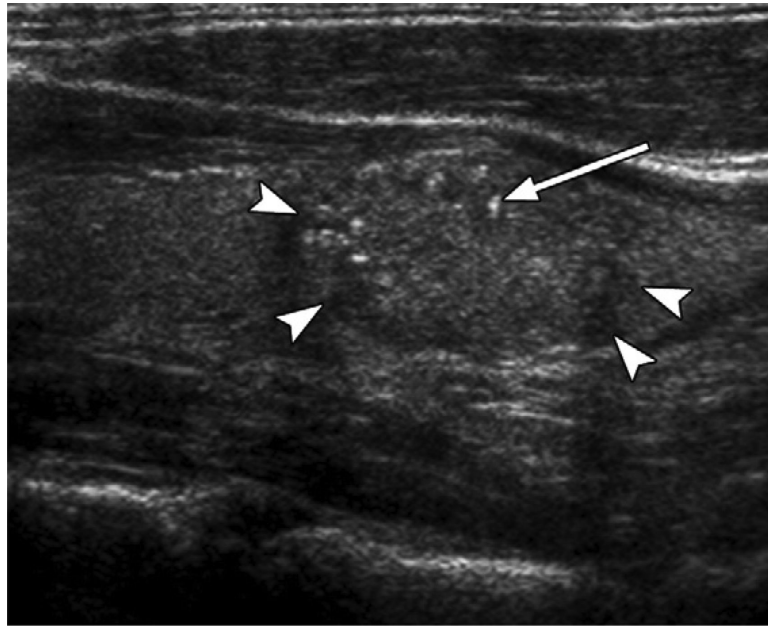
US image of a thyroid nodule (*arrowheads*) containing multiple fine punctuate echogenicities (*arrow*) with no comet-tail artifact, indicating high suspicion for malignancy. FNA and surgery confirmed PTC. (*Reproduced from Frates MC. Management of thyroid nodules detected at US: Society of Radiologists in Ultrasound consensus conference statement. Radiology 2005;237:794–800; with permission.*)
